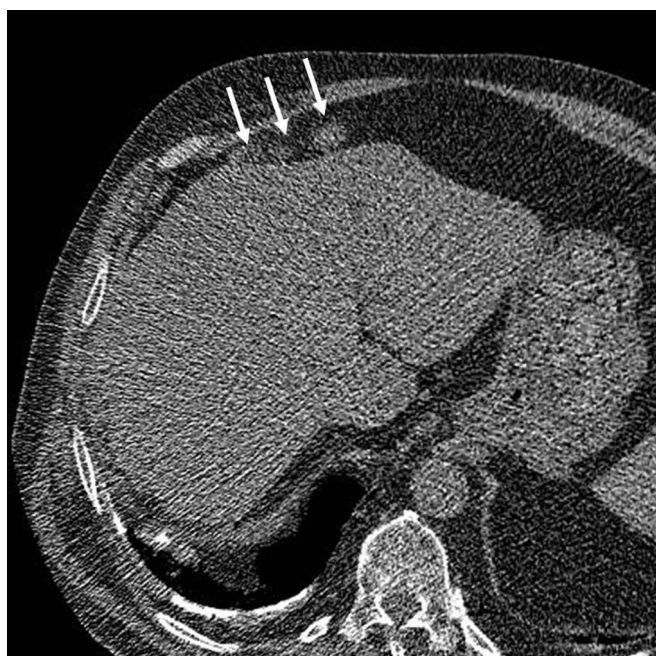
Annual repeat screening low-dose computed tomography (LDCT) of a 68-year-old man. The annual repeat demonstrates intra-abdominal, prehepatic soft tissue nodules which were not present on the baseline. Subsequent investigations revealed a malignant peritoneal mesothelioma.
